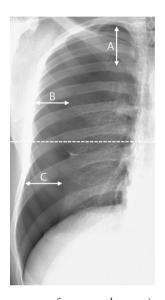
Measurement of pneumothorax size by interpleural distance on chest radiograph. It was measured at three locations: the apex (A) and the midpoints of the upper (B) and lower (C) halves of collapsed lung. The dash line means the borderline between the two halves. The formula to calculate the percentage of pneumothorax size using Collins method is $4.2 + \{4.7 \times (A + B + C)\}$.
